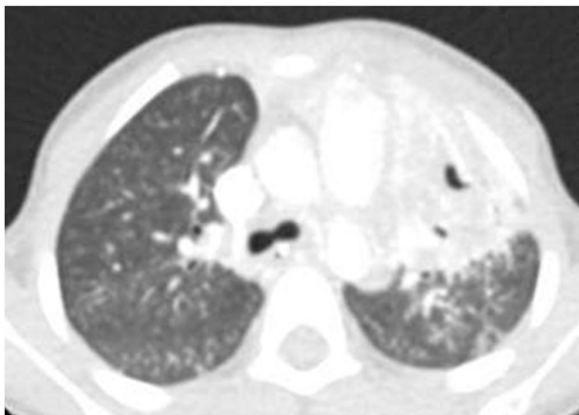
Computed tomographic scan of the chest of the patient demonstrating a left upper lobe cavitory lesion.
